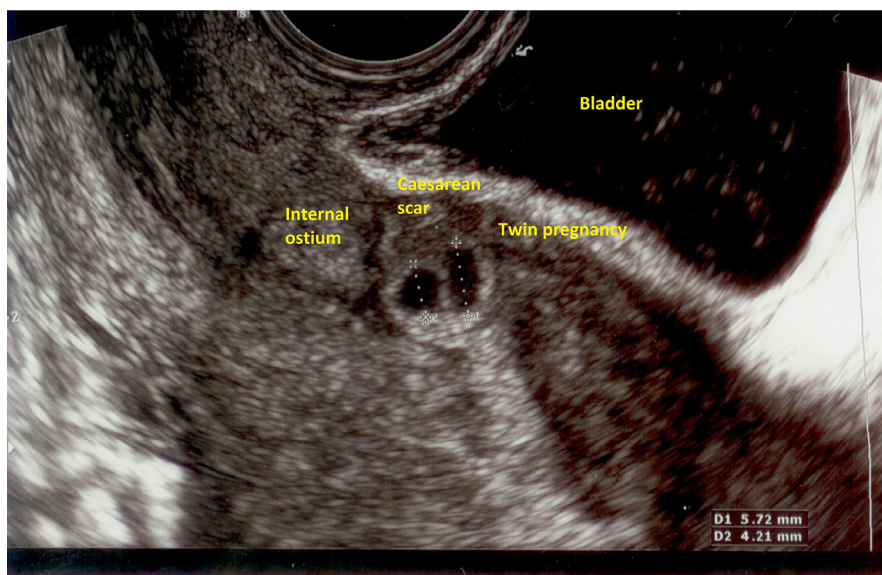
Sagittal transvaginal ultrasound imaging of twin Caesarean scar pregnancy showing two gestational sac anchored to Caesarean scar and empty uterine cavity.
